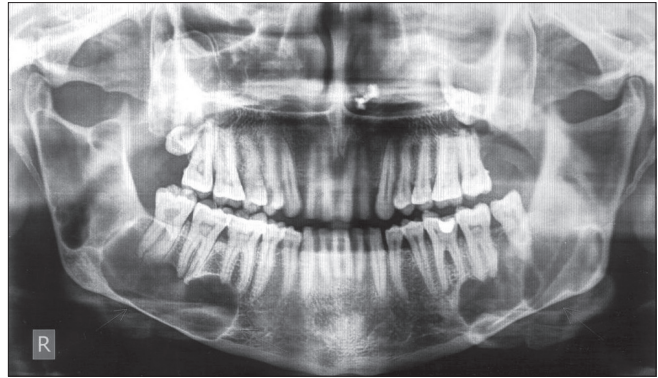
Patient 2: Panoramic radiographs showing multilocular appearance of the lesion
